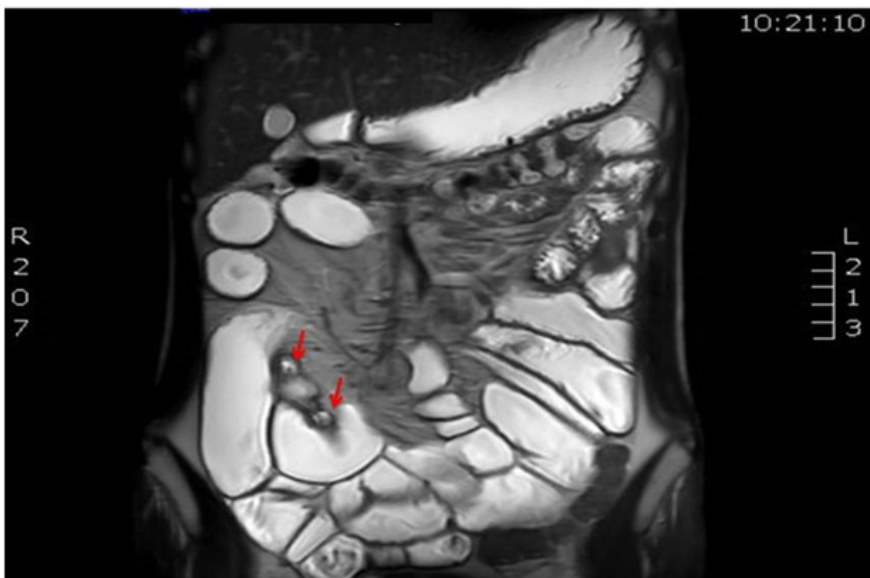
MRI enterography, red arrows: fistulas
